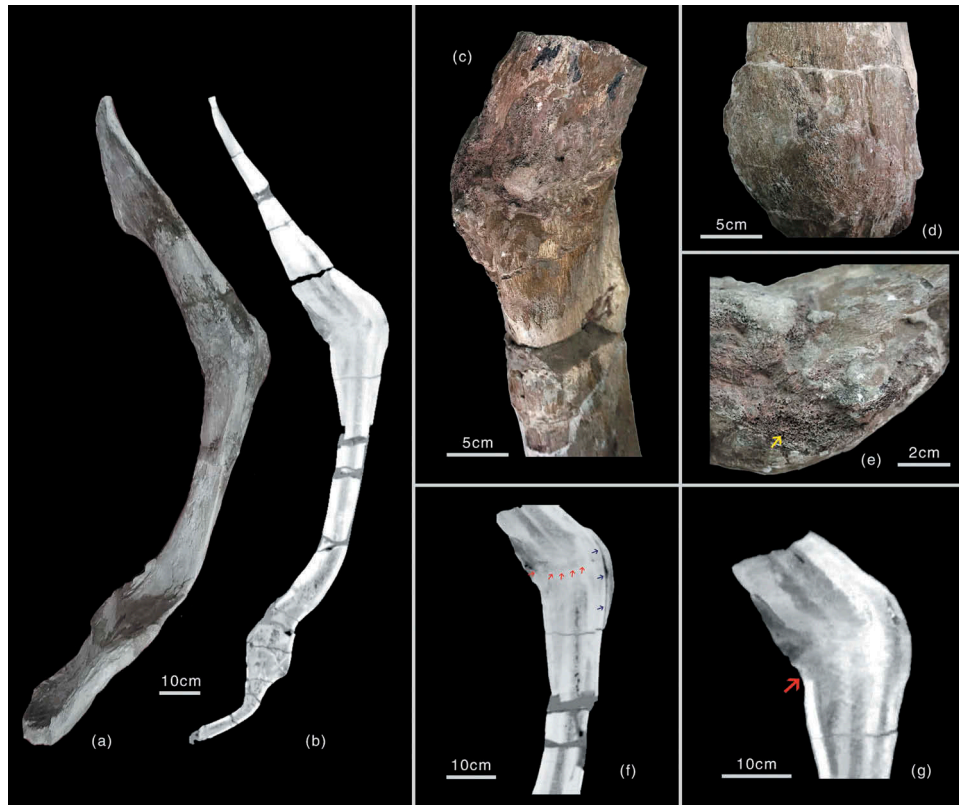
Analysis of the fracture of the left scapula of *Yangchuanosaurus hepingensis*. (a) morphological image of the left scapula of *Y. hepingensis* in medial view; (b) CT image of the left scapula of *Y. hepingensis*; (d) the expanded area of the fracture; (e) detailed image of the fracture, visible honeycomb structure; (f) CT image of the fracture area, red arrow indicates the fracture line, the yellow arrow shows the trace line of the poroma attached to the bone cortex; (g) detailed CT image of the fracture area.
